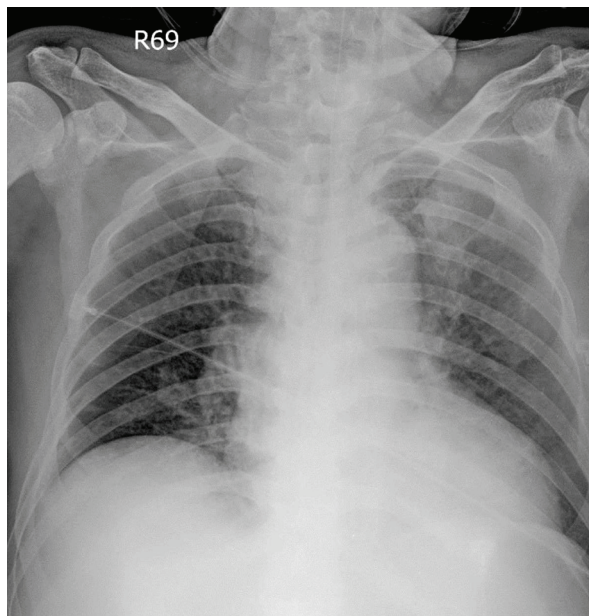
Chest radiograph revealed a new ill-defined hazy opacity at the left upper lung.
